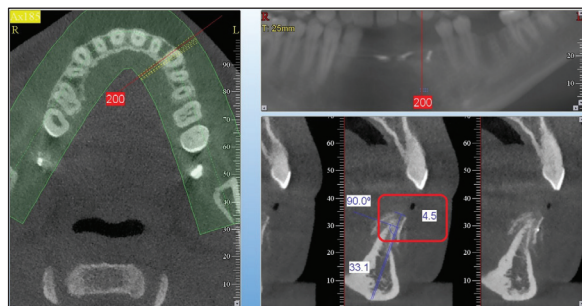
CBCT scan – width measurement at the 0 point.
